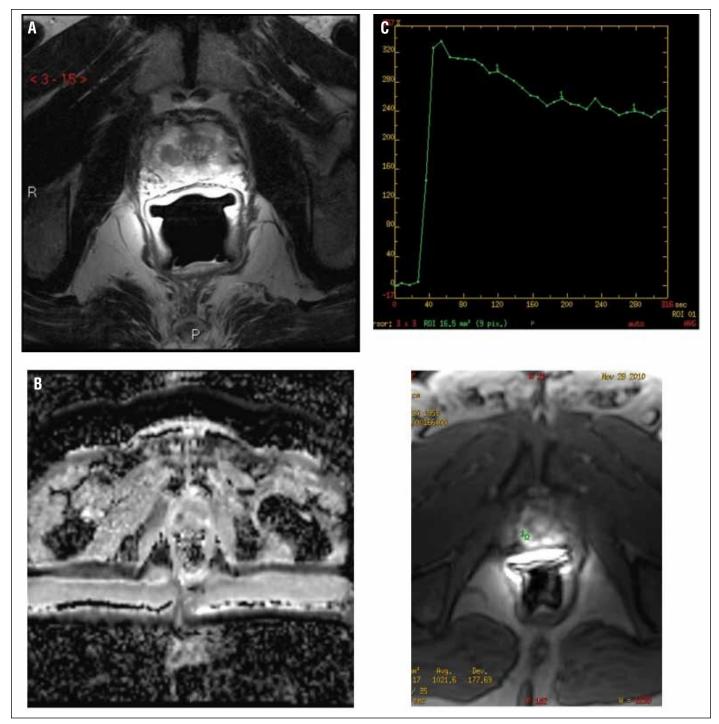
3T emMRI appearance of localized prostate cancer classified cT2c. These specific sequences show hyposignal on T2 imaging (2A), restriction of diffusion imaging (2B) and rapid and homogenous contrast enhancing with rapid washout (2C). No extracapsular extension features are seen in these images. 3T emMRI: 3 tesla endorectal coil multiparametric magnetic resonance imaging.
